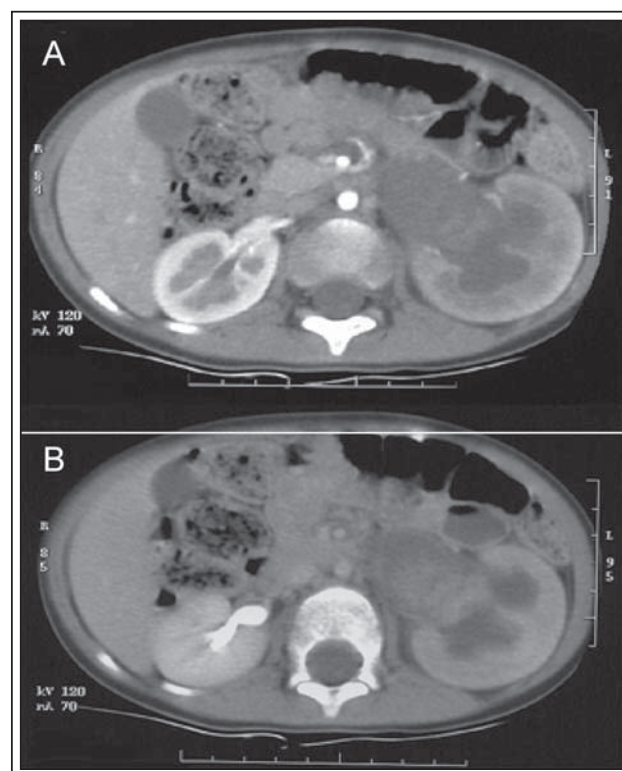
Computed tomography of the abdomen with contrast demonstrating a minimally enhancing, heterogeneous mass in the left renal pelvis on arterial phase (A) and excretory phase (B).
